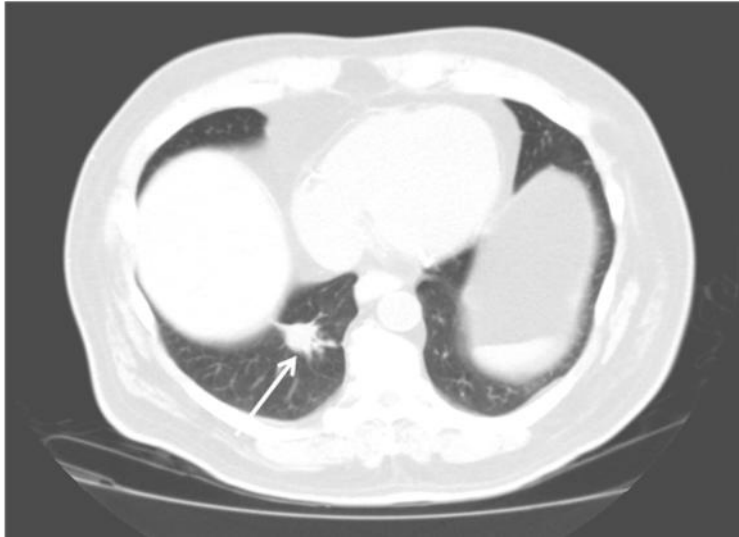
Chest CT showing noncalcified, spiculated 2.1 cm nodule in the right lower lobe indicated by the arrow.
